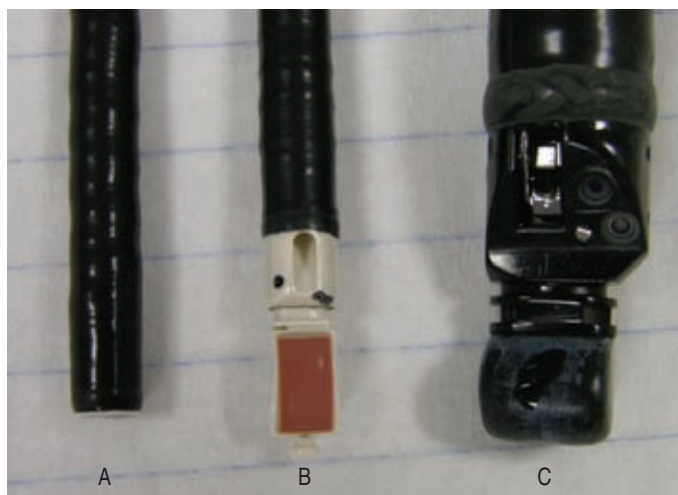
A) Standard videobronchoscope. B) Endobronchial ultrasound, which allows real-time ultrasound-guided transbronchial needle aspiration. C) Endoscopic ultrasound, which allows real-time ultrasound guided fine-needle aspiration and biopsy.
